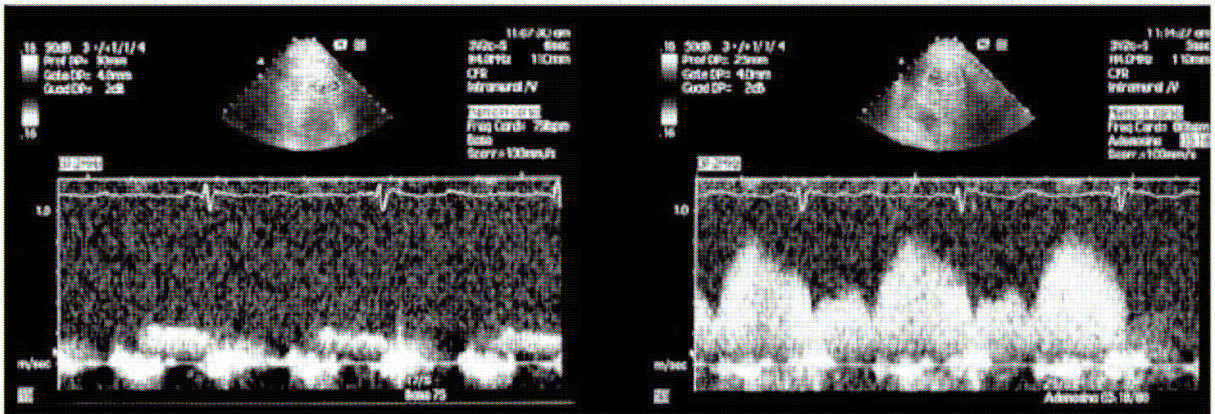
Coronary flow response to adenosine- Coronary flow velocity at rest (left) and during adenosine infusion (right) by transthoracic echocardiography
